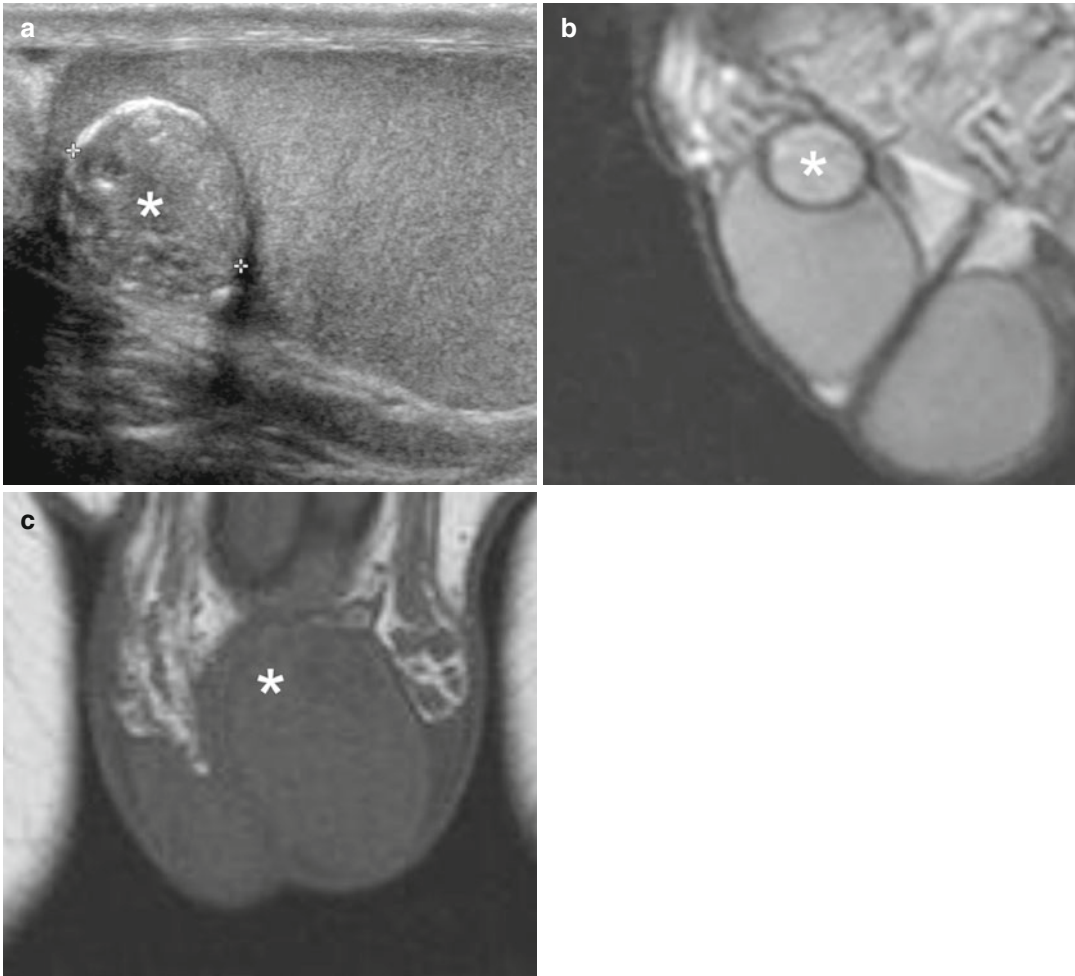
Epidermoid cyst presenting as a palpable nodule of the left testis. (a) Grayscale ultrasonography showing a slightly inhomogeneous lesion isoechoic to the surrounding normal tissue of the testis, with a few wall calcifications (*asterisk*). (b) Sagittal T2-weighted image shows a
